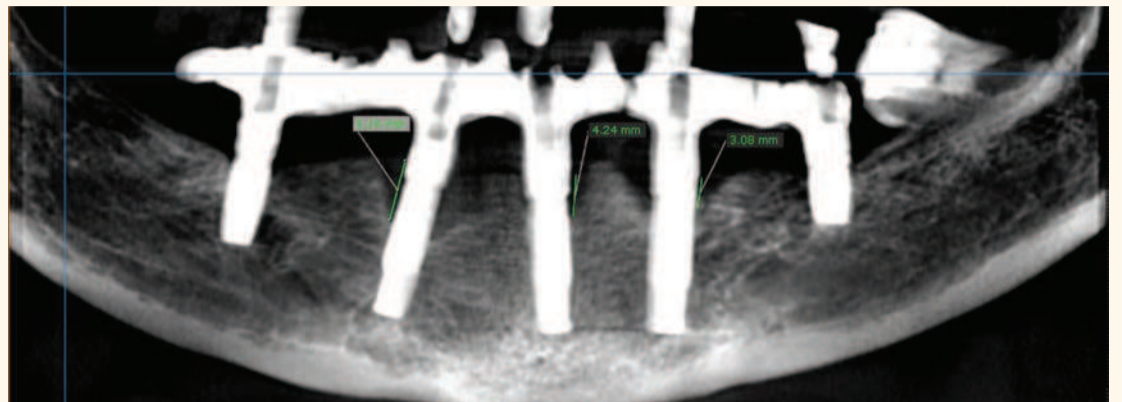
Radiographic assessment at baseline.
